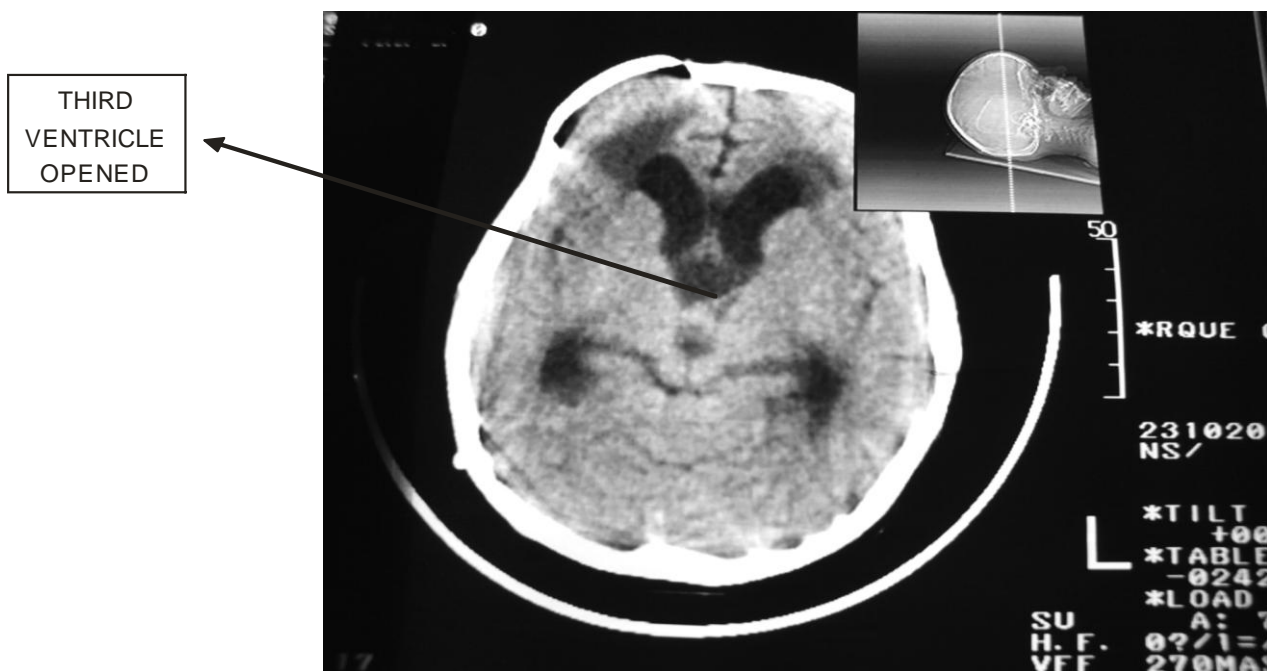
Post Operative CT Scan Film Showing Excision of Cystic Lesion in Third Ventricle.
